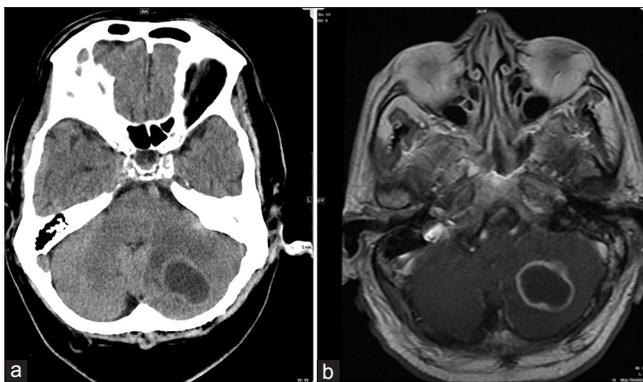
(a) Noncontrast head CT shows a cavitory lesion with perilesional edema and mass effect upon the 4th ventricle. (b) Contrast enhanced MRT1 sequence shows a well circumscribed left cerebellar hemispheric lesion with prominent rim enhancement. There is associated vasogenic edema compressing both the fourth ventricle and medulla
